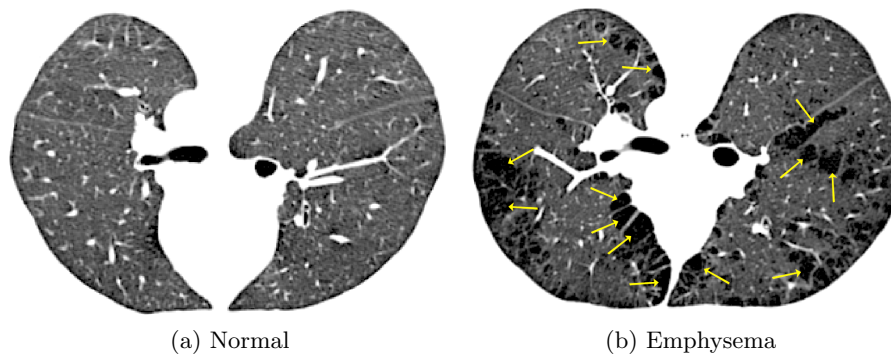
An example of a CT lung slice with normal and emphysematous lung parenchyma. Arrows point to examples of large regions with emphysematous tissue, so-called bullae.
